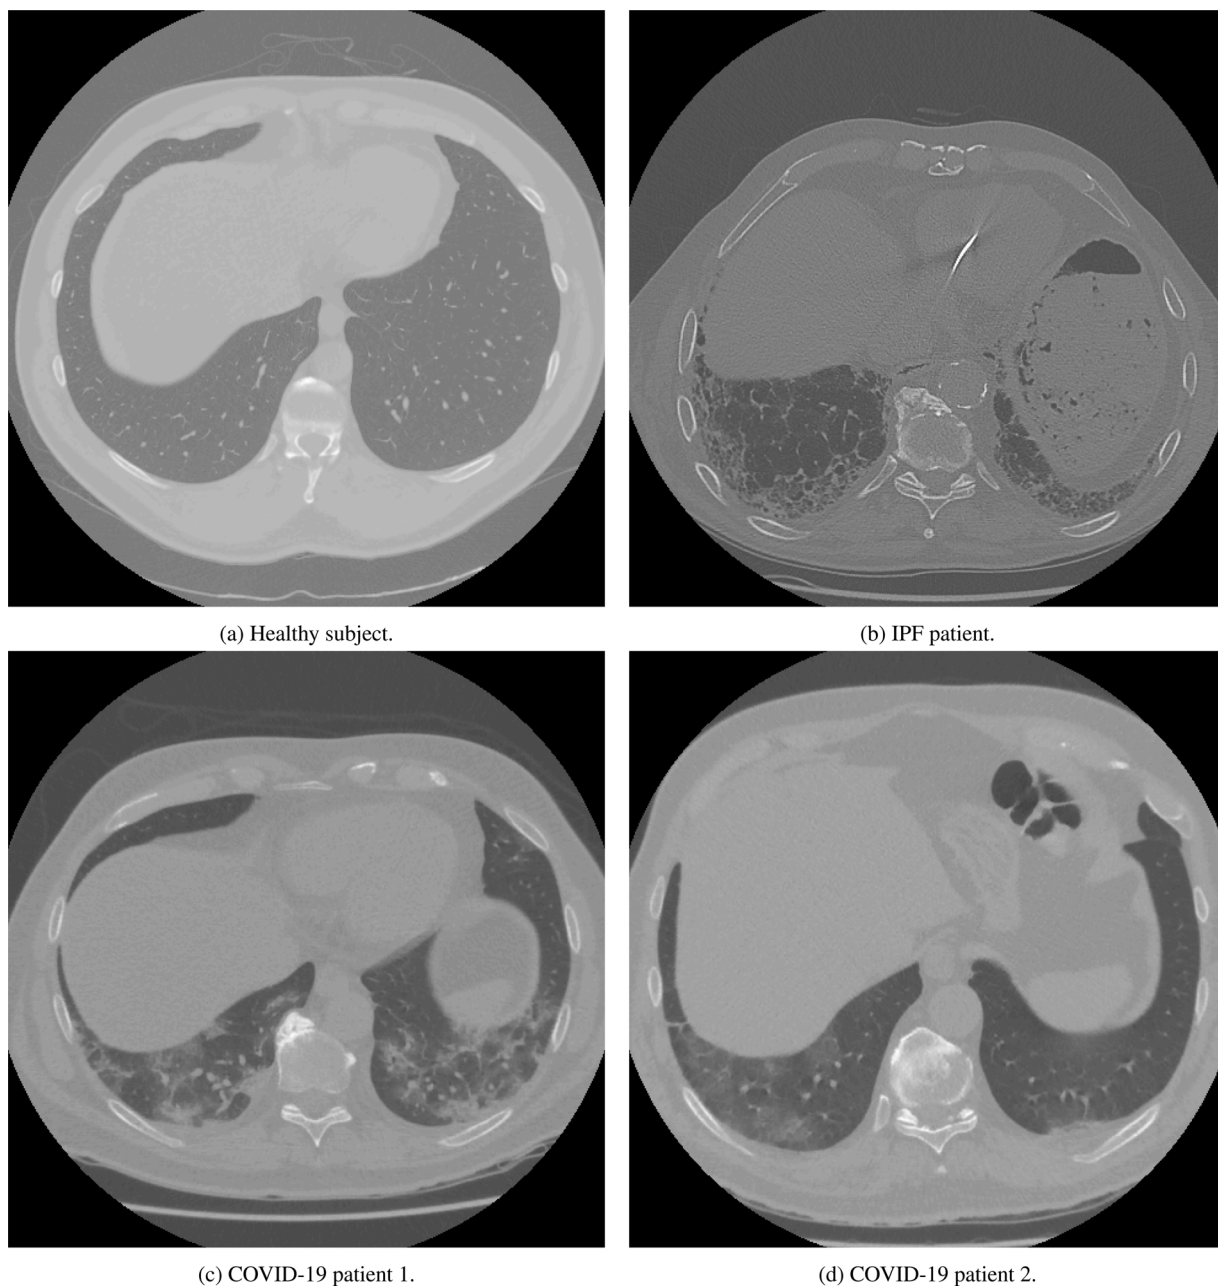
CT scans examples of a healthy person (a), idiopathic pulmonary fibrosis (IPF) (b), and Coronavirus disease 2019 (COVID-19) patients (c and d).
